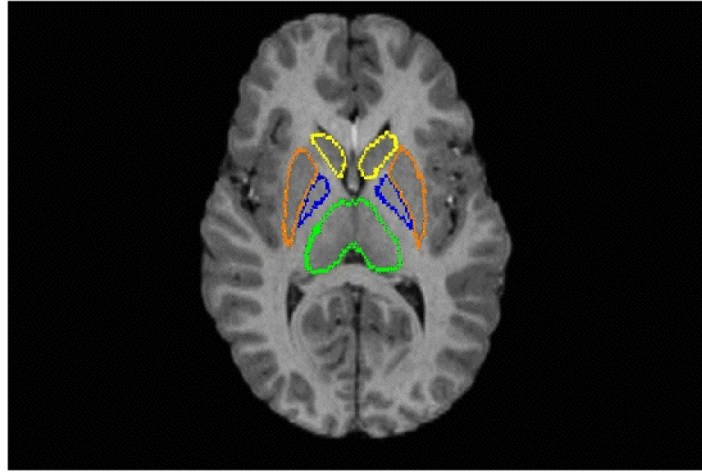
MRI in the axial plane from a 3 year-old child with ASD showing tracings of caudate in yellow, putamen in orange, globus pallidus in blue and thalami in green.
